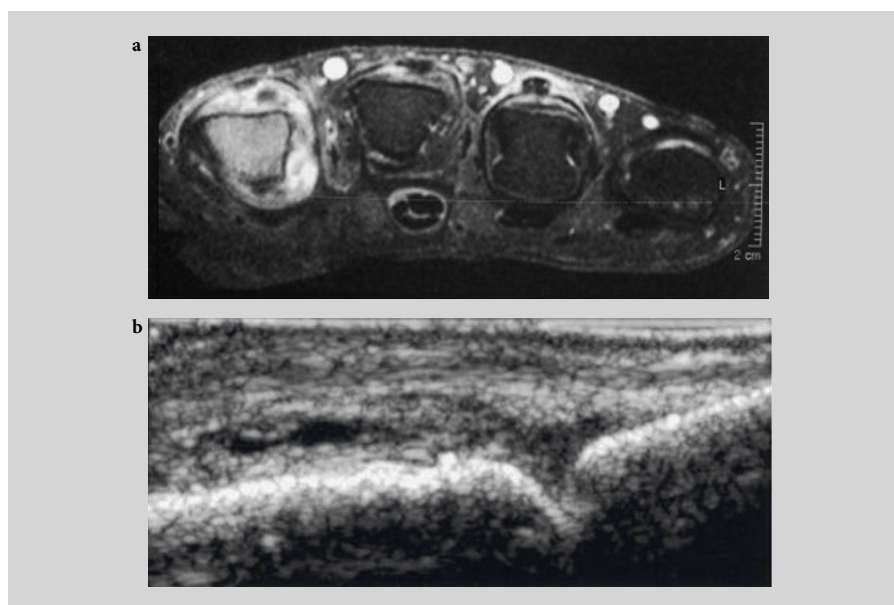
Imaging detected synovitis in patients with RA in clinical remission. Axial section of a T1 spectral presaturation with inversion recovery, postgadolinium magnetic resonance imaging scan of the metacarpophalangeal (MCP) joints of the right hand of a patient with rheumatoid arthritis in clinical remission, demonstrating synovitis in the second MCP joint, flexor tenosynovitis of the third flexor tendon, and extensor tenosynovitis of the third and fourth extensor tendons (a). Longitudinal section of an ultrasonography scan of the second MCP joint of the right hand of a patient with RA in clinical remission, demonstrating grayscale changes of synovial hypertrophy (b). L, left.
